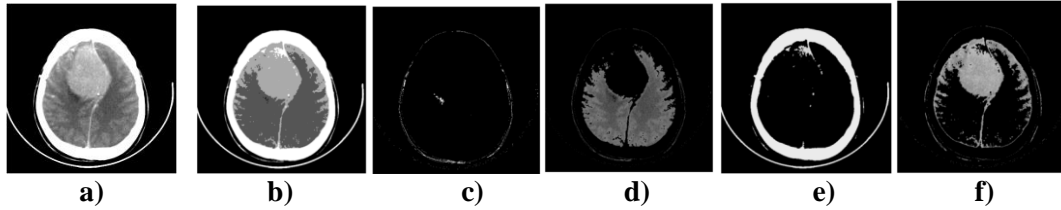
12 Fuzzy k-means algorithm applied on CT slice. a) Original CT slice, b) Clustered CT slice, c) Objects in cluster 1, d) Objects in cluster 2, e) Objects in cluster 3, f) Objects in cluster 4.
